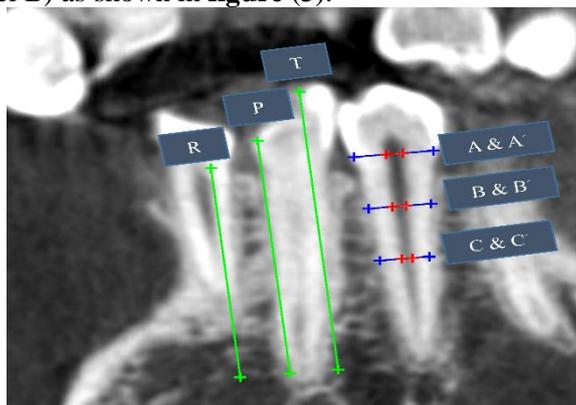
Length and width measurements performed according to Kvaal et al.'s approach on CBCT sagittal sections in mandibular first premolar
